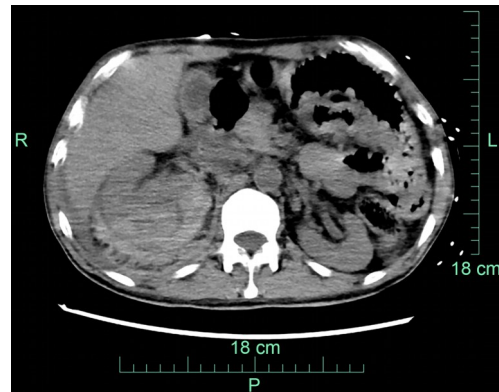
Ruptured right kidney shown by abdominal computed tomography (CT). L: left; R: right; P: posterior.
